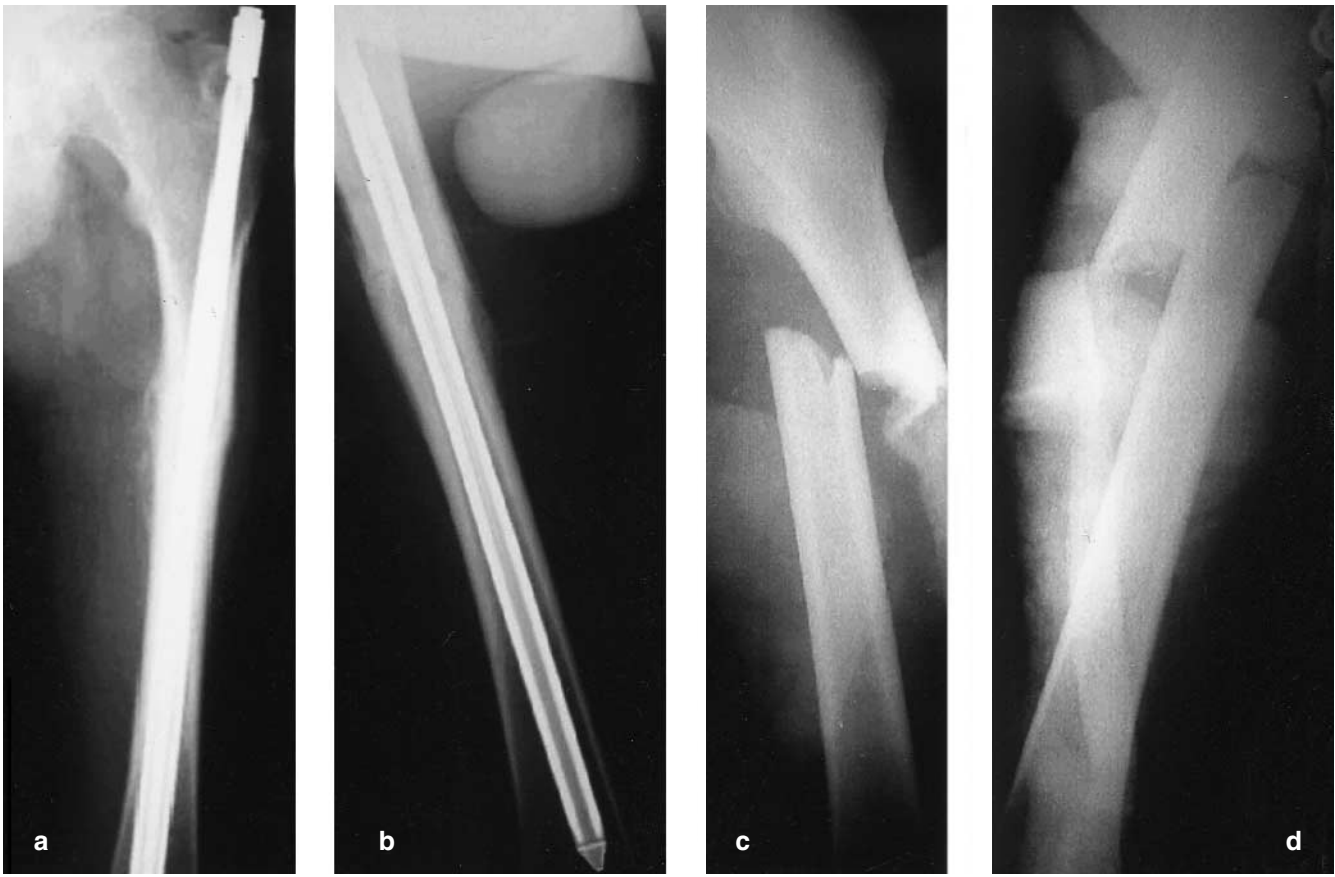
Femoral shaft fractures (type 32A2.1). a, b Preoperative views of two patients. c, d X-rays at 9 weeks with complete consolidation
